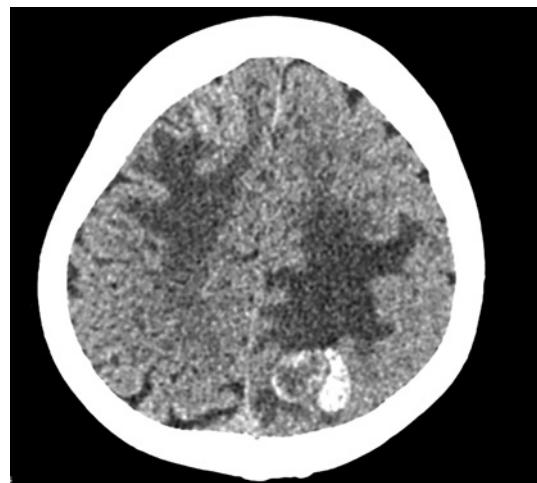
CT demonstrated the emergence of bleeding from brain metastasis on the left parietal lobe.
